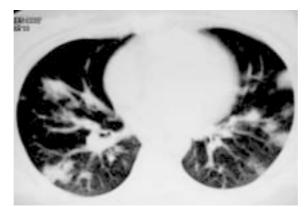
CT of the thorax taken at the level of the basal segments of the lower lobes.
